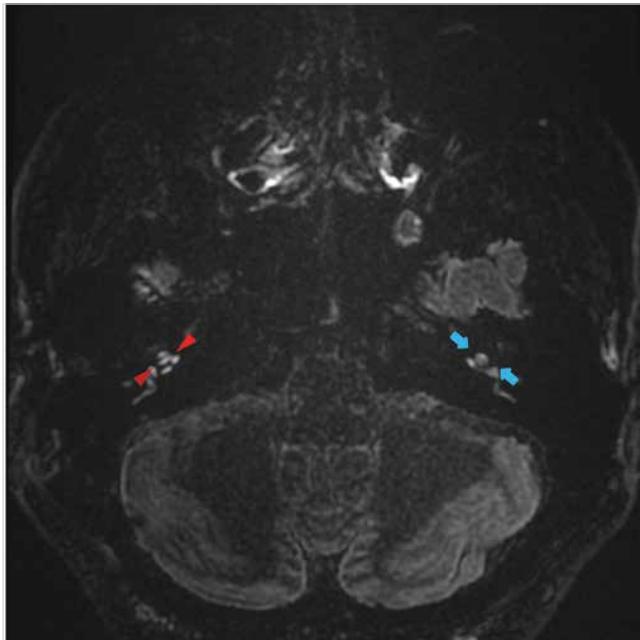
65-letnia kobieta z podejrzeniem choroby Méniere'a po stronie lewej. Przekrój osiowy na poziomie przedzionków, w sekwencji 3D FLAIR, 4 godziny po dożylnym podaniu podwójnej dawki środka cieniującego. Po stronie lewej widoczne poszerzone woreczek i łagiewka, nie jest widoczne brzeżne wzmacnienie przedzionka. Obraz odpowiada stopniowi II wodnika przedzionka wg klasyfikacji Baratha (czerwona strzałka). Po stronie prawej obraz prawidłowego wzmacnienia przedzionka oraz nie wzmacniających się woreczka i łagiewki (niebieska strzałka).
